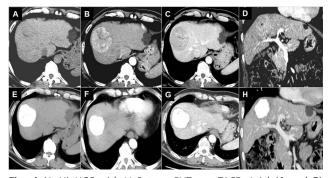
(A–H) HCC with Vp3 type PVT: pre-TACE—Axial (A and B) and coronal (C and D) images showing HCC in right lobe of liver invading portal vein (Vp3) with arterioportal shunting. Post-TACE follow-up 6 month CT Axial (E–G) and coronal (H) images showing the reduced size of target lesion without any enhancement s/o complete response. CT, computed tomography; HCC, hepatocellular carcinoma; PVT, portal vein tumor; TACE, transarterial chemoembolization; vp,Portal vein invasion.
